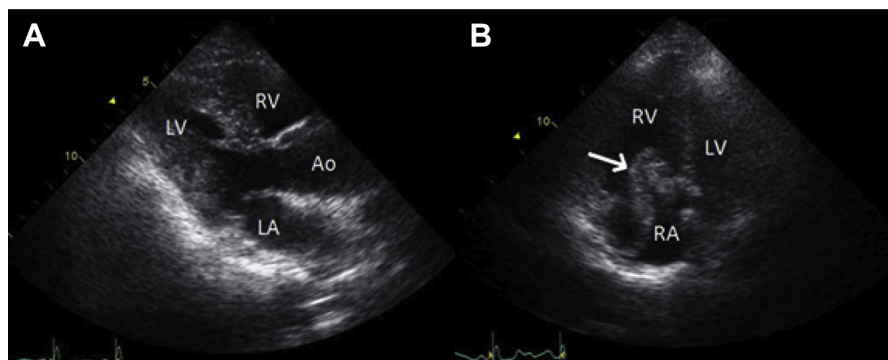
Transesophageal echocardiogram showing A) Normal left ventricle size and function; B) Dilated right ventricle with large right atrial thrombus extending into the right ventricle (white arrow).
